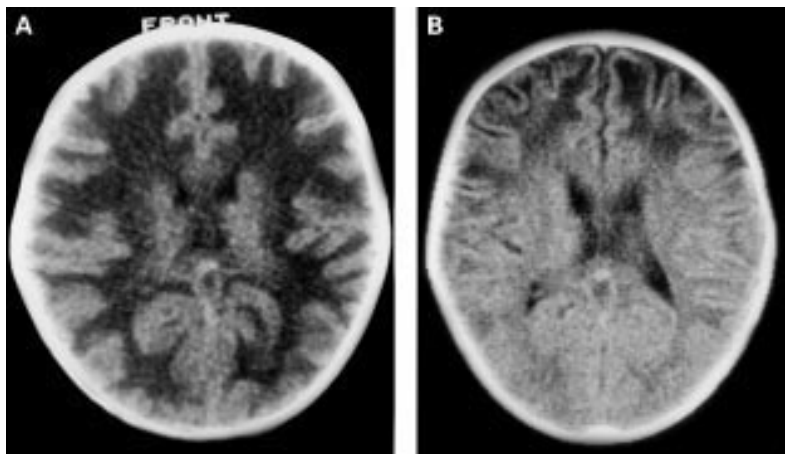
Computed tomograms showing (A) pronounced low attenuation throughout the cerebral white matter and (B) partial resolution of white matter changes but to a lesser extent in the frontal lobes.
